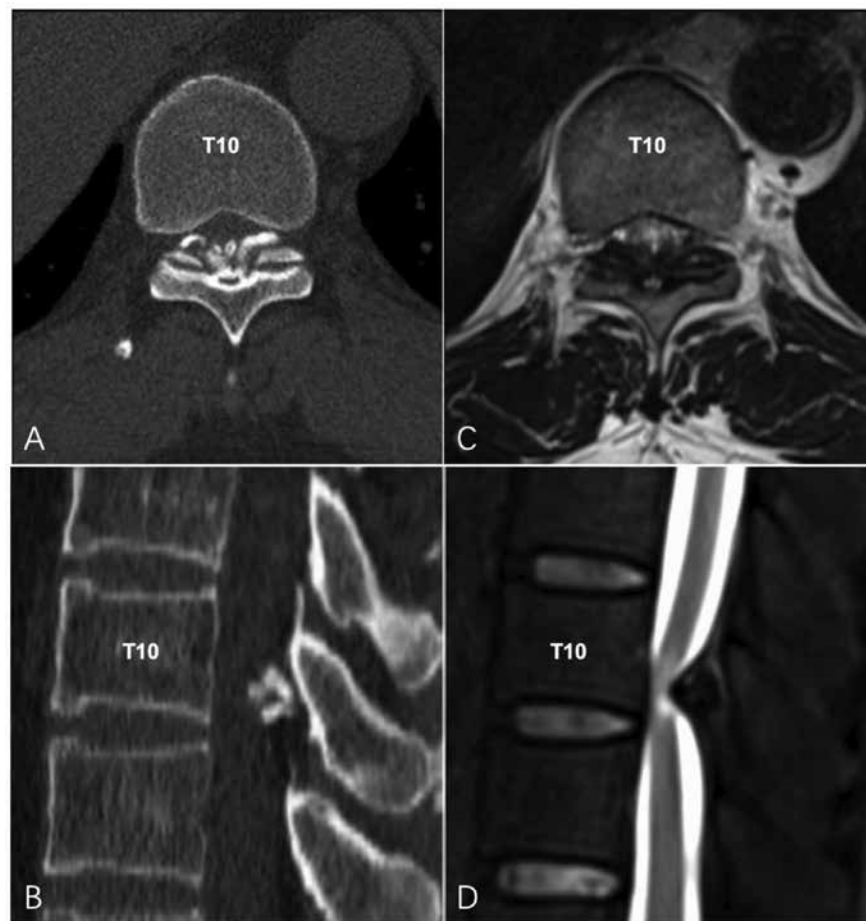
Preoperative CT and MRI. A. Axial CT scan showed fused type TOLF (Sato classification) at T10-11 level. B. Sagittal CT showed TOLF at T10-11 level severely compression on the spinal cord. C. Axial T2 weighted MRI showed dorsal compression of TOLF on the spinal cord. D. Sagittal FSI T2 weighted MRI showed compressed spinal cord by TOLF from dorsal aspect.
